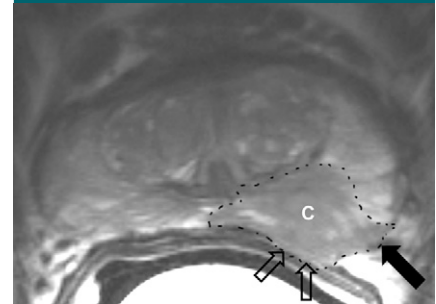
Multiparametric MR imaging in prostate cancer staging in a 70-year-old man with PSA level of 12 ng/mL and well-differentiated prostate carcinoma (C). Axial T2-weighted turbo spin-echo MR image (4260/99; flip angle, 120°) shows low-signal-intensity region (outline) in left peripheral zone. Bulging and obliteration of rectoprostatic angle (open arrows) indicate extracapsular extension. There is invasion of the neurovascular bundle (solid arrow). At MR imaging, stage T3a prostate cancer was reported. Radical prostatectomy revealed a solitary adenocarcinoma with Gleason score 7 (3+4) with extraprostatic extension (stage T3a).
